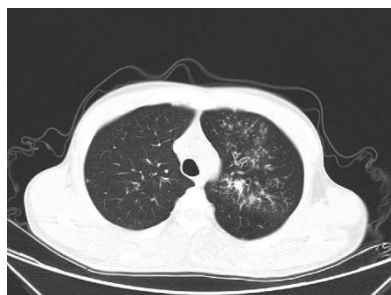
CT scan of the lungs showed that the bronchi of the upper lobe of both lungs were slightly dilated, with multiple nodules around them, and large flaky dense plaques in the upper lobe of the left lung, which were considered to be infectious lesions. Calcified lymph nodes in mediastinum and right hilum
